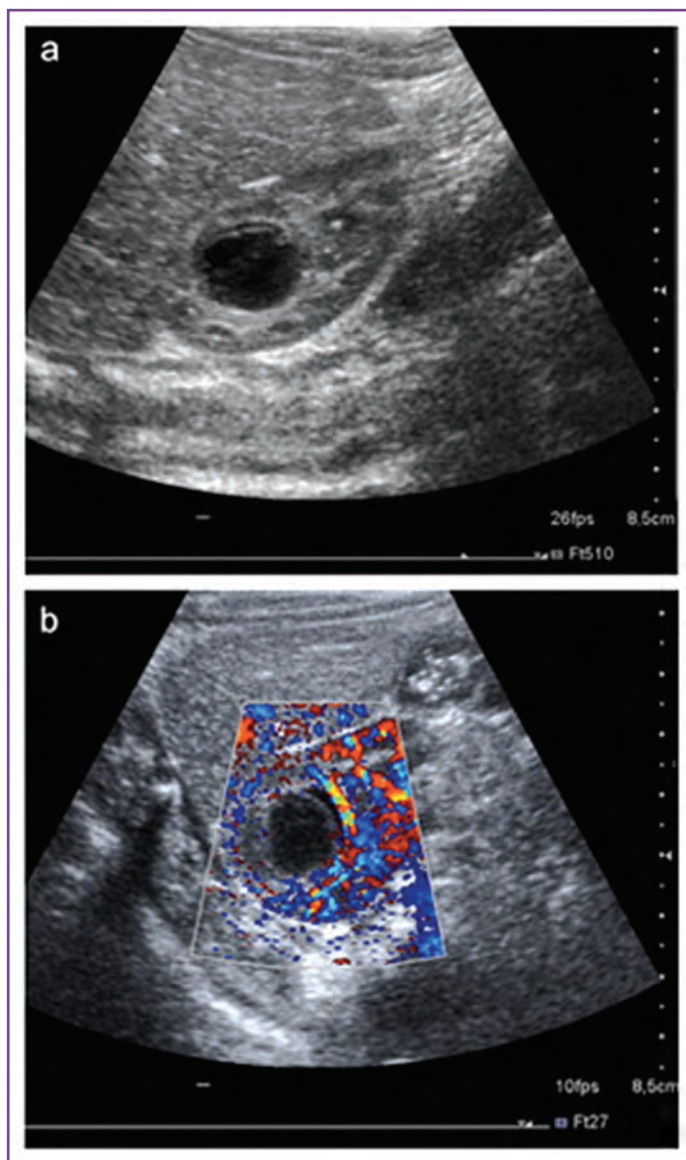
Pediatric renal ultrasonographic images depict a renal abscess. A, A hypoechoic region within the renal parenchyma is surrounded by a thin, hyperechoic rim. B, Power Doppler image shows no vascular signal within the central area but a well-vascularized periphery.
